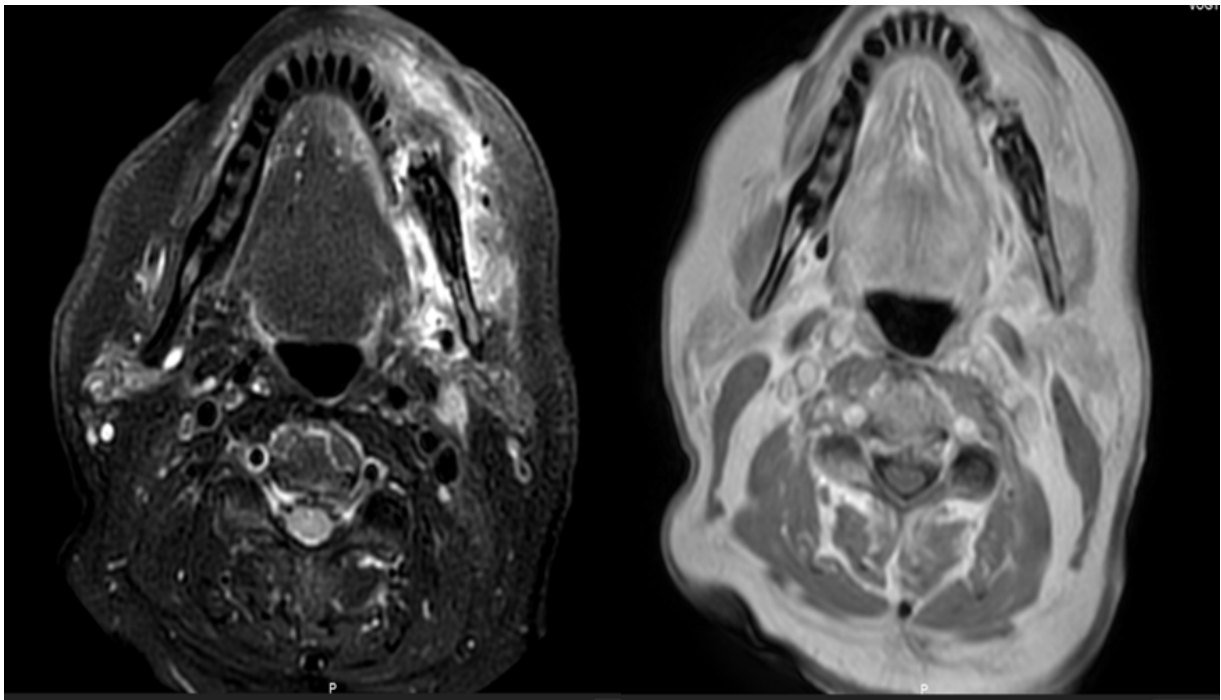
Axial MRI images: T2-weighted (A) and T1-weighted (B) sequences showing a left mandibular lesion with high signal intensity, suggestive of a solitary plasmacytoma.
